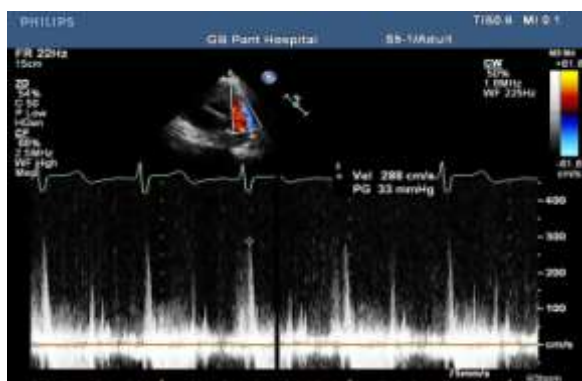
2D Echo of patient E with doppler studies revealed bidirectional flow across the septal defect (ES).
